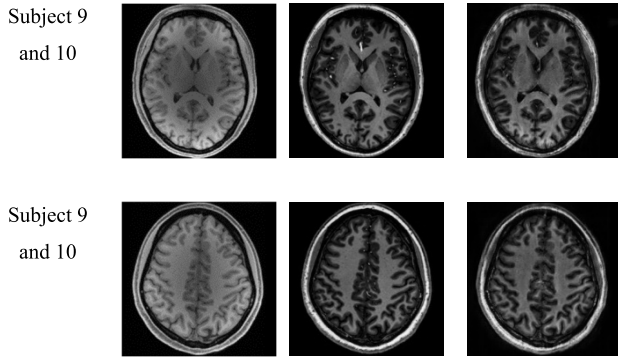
(Continued.) 7T MRI generated from 3T MRI on each test set by the resnetgen9_patchGAN_MSE model.
